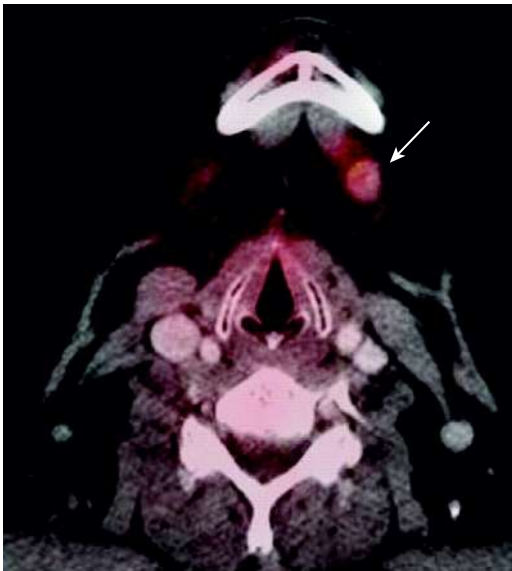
Palpable submental lymph node with FDG uptake. Axial fused contrast-enhanced PET/CT image shows enlarged left submental lymph node (arrow) with increased FDG uptake. Lesion was biopsied and was consistent with sarcoidosis. (From Prabhakar HB, Rabinowitz CB, Gibbons FK, et al. *Imaging features of sarcoidosis on MDCT, FDG PET, and PET/CT*. *AJR Am J Roentgenol*. 2008;190:S1–S6, Fig. 5, p. S3.)
